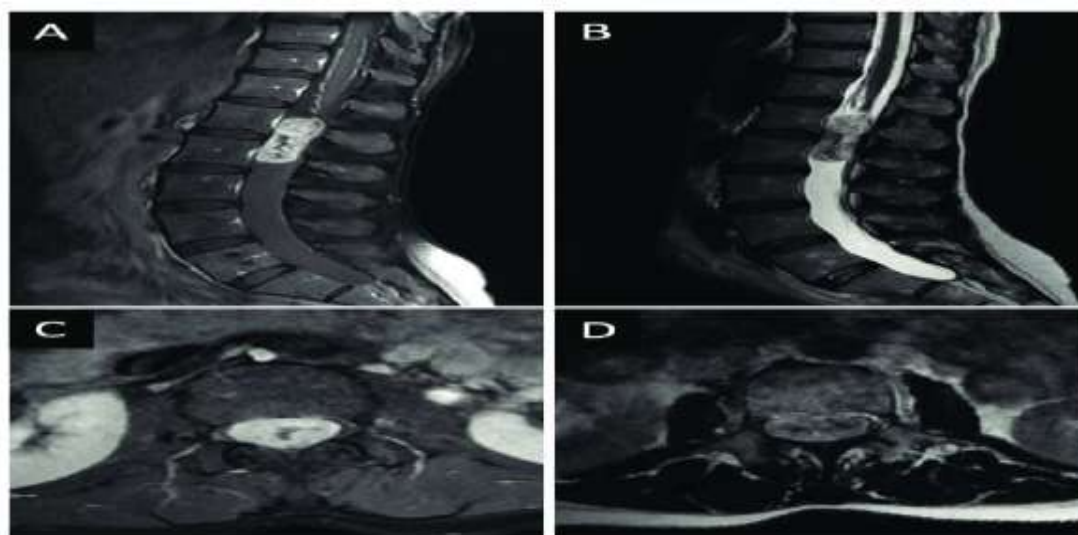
MRI showing myxopapillary ependymoma. (A) Contrast-enhanced sagittal T1-weighted MRI demonstrating a well-defined enhancing intradural lesion in the distal spinal cord region. (B) Sagittal T2-weighted MRI showing a hyperintense intradural lesion involving the conus medullaris/filum terminale region. (C) Axial post-contrast MRI demonstrating enhancement of the lesion within the spinal canal. (D) Axial T2-weighted MRI showing compression and displacement of the adjacent cauda equina nerve roots by the lesion.
